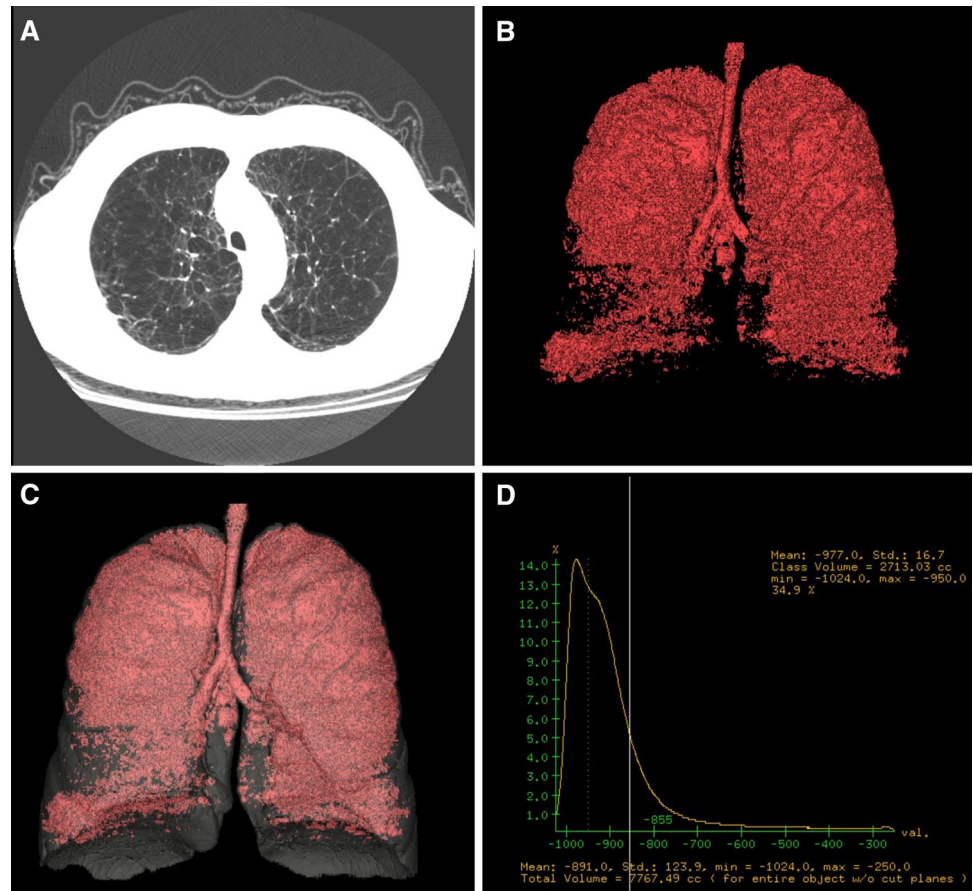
45-year-old woman with alpha-1 antitrypsin deficiency. a Coronal CT image demonstrating extensive areas of low attenuation and bronchial wall thickening, mainly in the lower lobes. b Three-dimensional CT reconstruction demonstrating emphysematous areas
